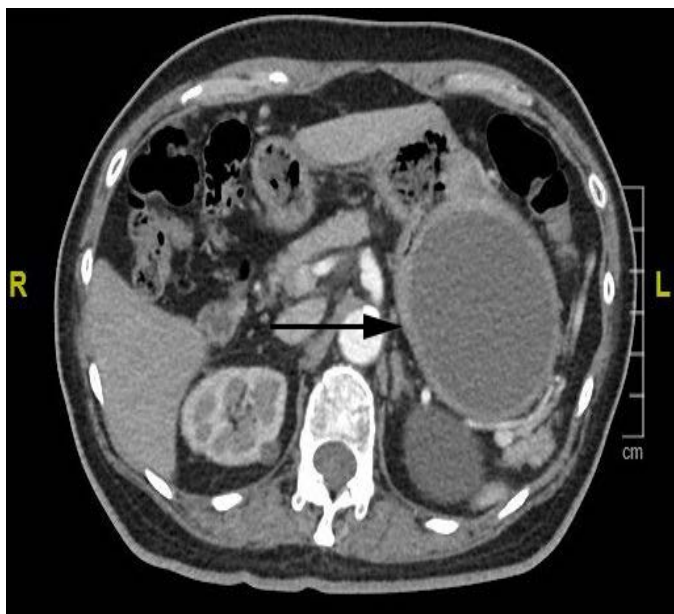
Abdominal computed tomography (CT) scan demonstrating a large cystic lesion adjacent to the gastric fundus (arrow).
